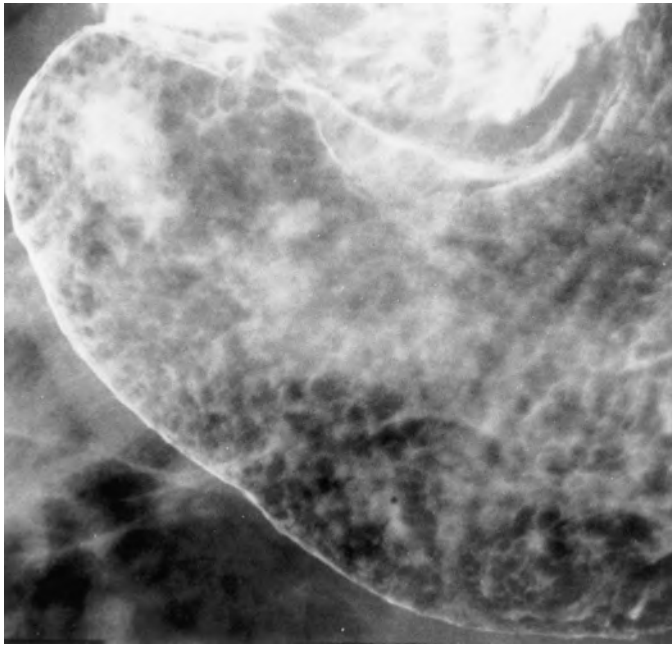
Low-grade gastric MALT lymphoma. There are multiple round, variably sized, confluent nodules with poorly defined borders in the gastric antrum. These findings are characteristic of gastric MALT lymphoma. In contrast, the nodules of lymphoid hyperplasia have more discrete borders and a more uniform size (see Fig. 30-12). (From Yoo CC, Levine MS, Furth EE, et al: *Gastric mucosa-associated lymphoid tissue lymphoma: Radiographic findings in six patients*. *Radiology* 208:239–243, 1998.)
